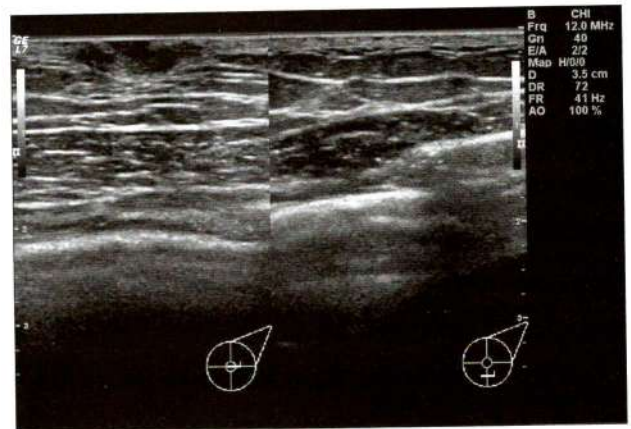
Ultrasound finding show normal nipple without retroglandular tissue of the right breast
